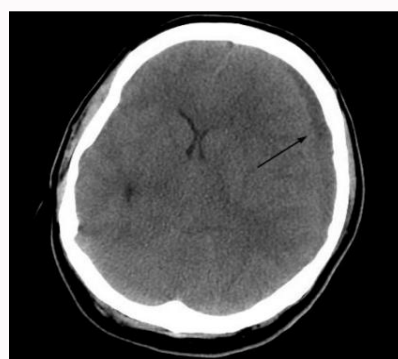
Coronal image of CT head without contrast. Arrow demonstrating 6 mm left hemispheric subdural collection resulting in subfalcine herniation and left-to-right midline.
